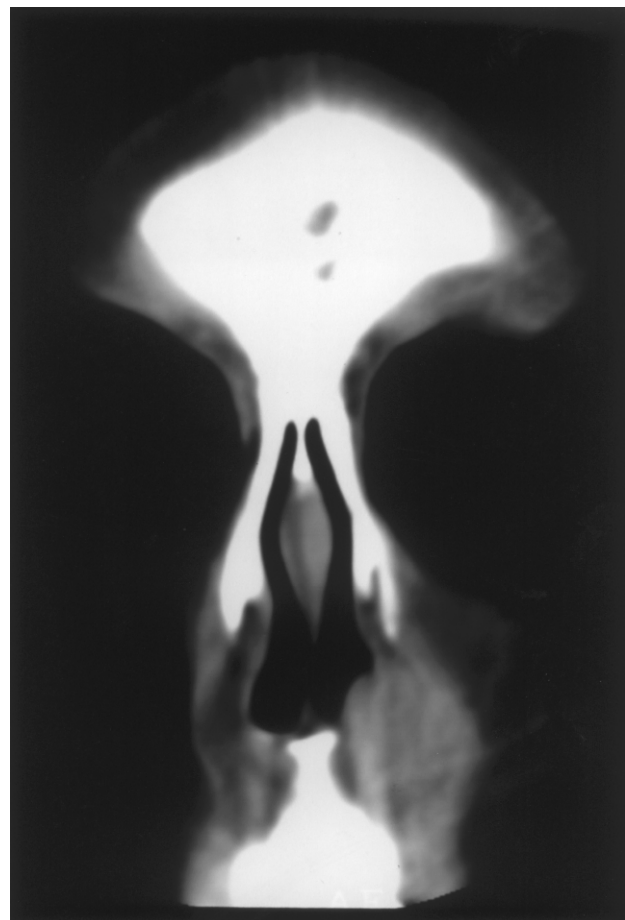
Preoperative CT scan showing a mass at the left alar base indenting the nasal aperture.
